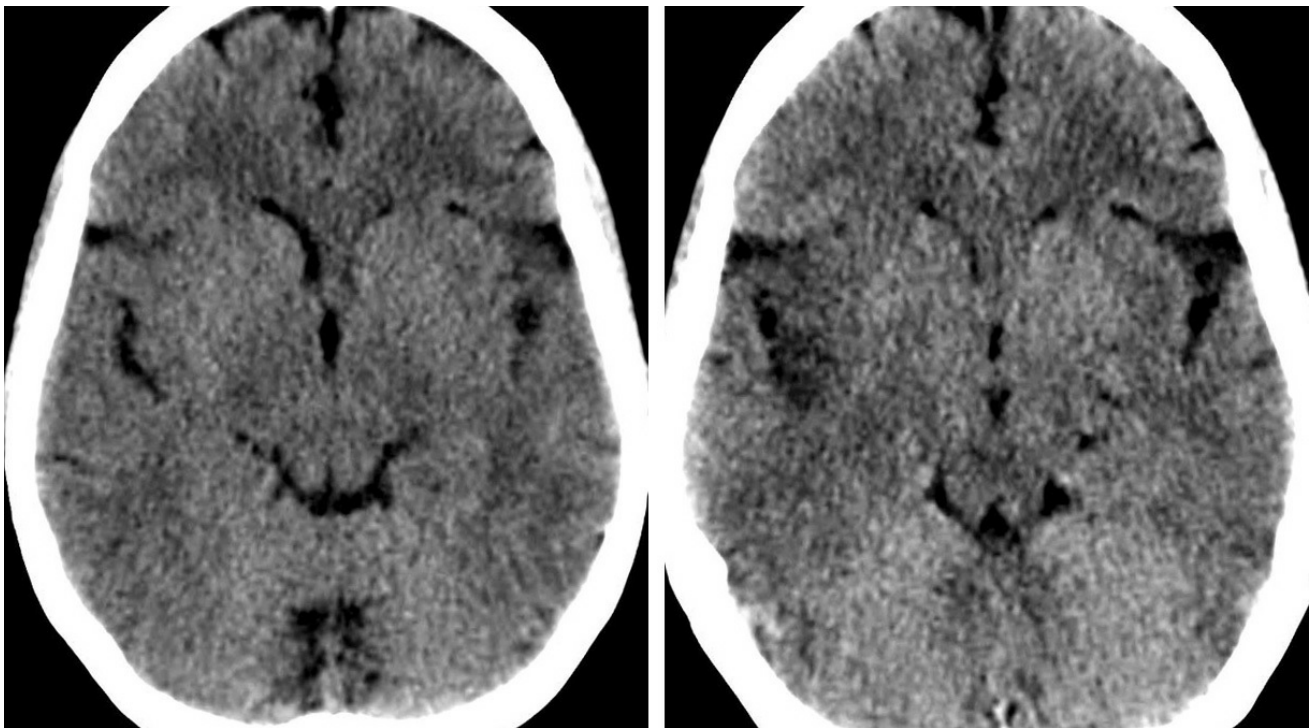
Noncontrast axial CT images of the head in this 70 year old patient with later confirmed herpes encephalitis. The left image shows a normal appearance of the brain. 3 days later (right), subtle hypodense edema has appeared in the right insular cortex.
